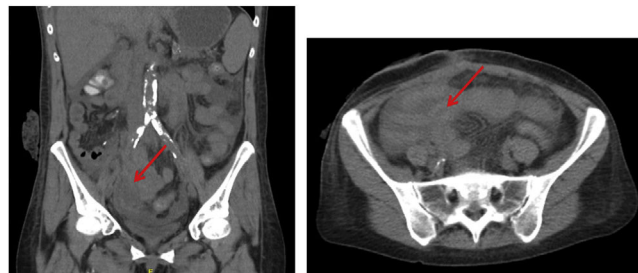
Abdominal-pelvic CT angiogram with intravenous contrast, coronal and sagittal images. Inflammatory phlegmon is seen in RIF (red arrow) in the region of the pancreatic graft, with no vascular alterations or contrast extravasation in the area.
